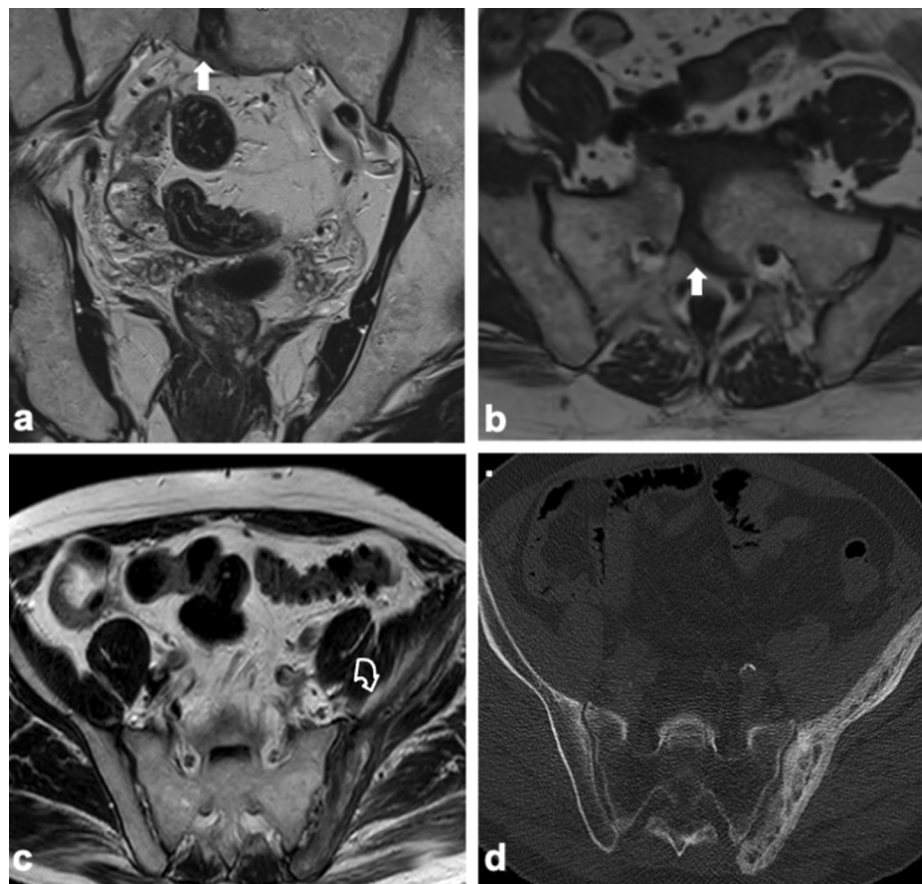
Coronal (a) and axial (b) T2w images show a cleft in the vertebral body of S1 (arrows), in keeping with Butterfly vertebra. Axial T2w image (c) scan shows thickened cortex, coarse trabeculation and bone sclerosis of the left iliac bone (curved arrow), then confirmed on axial CT image (d), suggestive of Paget disease. T2w T2-weighted, CT computed tomography.
